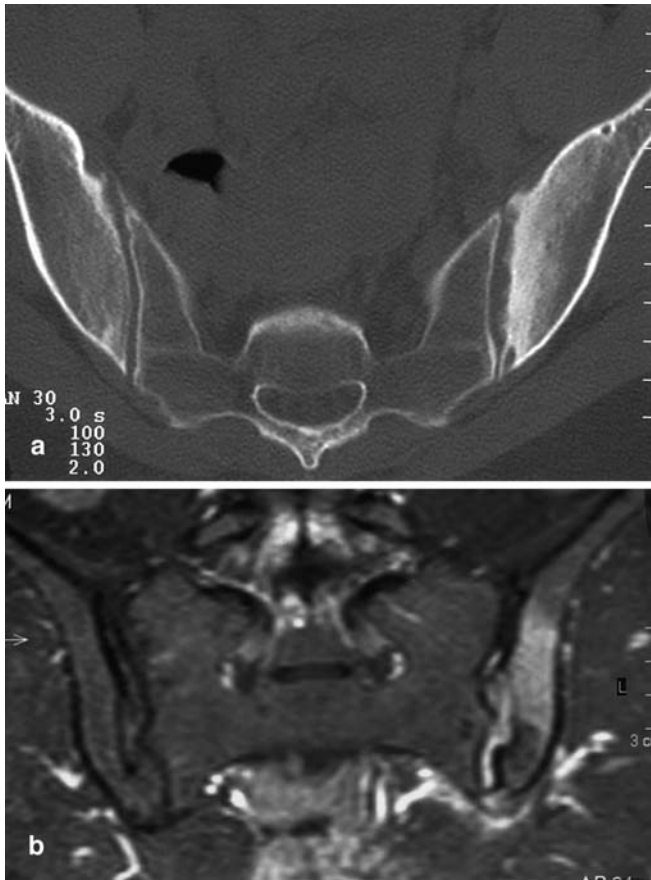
Chronic sclerosing osteomyelitis in a 37-year-old woman. No skin changes were present at the time of diagnosis. No bacteremia and no organism could be cultured from the aspirate (CT-guided puncture). The disease was classified as a “SAPHO-like”, “reactive” osteomyelitis. CT (a) revealed a sclerotic iliac focus with irregularities of the iliac margin of the SI joint. The sacral element of the SI joint is normal. MRI (b) (fat-suppressed T1-weighted spin-echo sequence after i.v. administration of gadolinium) additionally emphasized the involvement of the joint without any change in the sacrum
